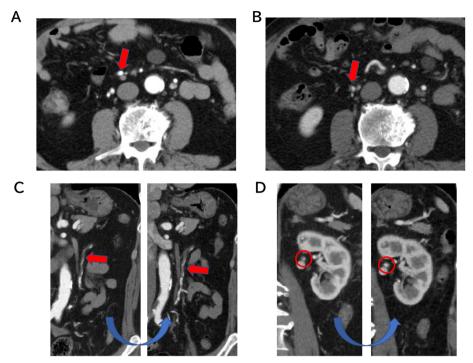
(A) Axial enhanced computed tomography (CT) on admission showed no dissection of the superior mesenteric artery (SMA) (red arrow). (B) Axial enhanced CT at three days post-admission after admission showed dissection of the SMA (red arrow). (C) The appearance of the IMA was not markedly different from that on the coronal CT performed two days earlier (red arrows). (D) The left renal artery's dissection had improved from the 2-days-prior coronal CT (red circles).
